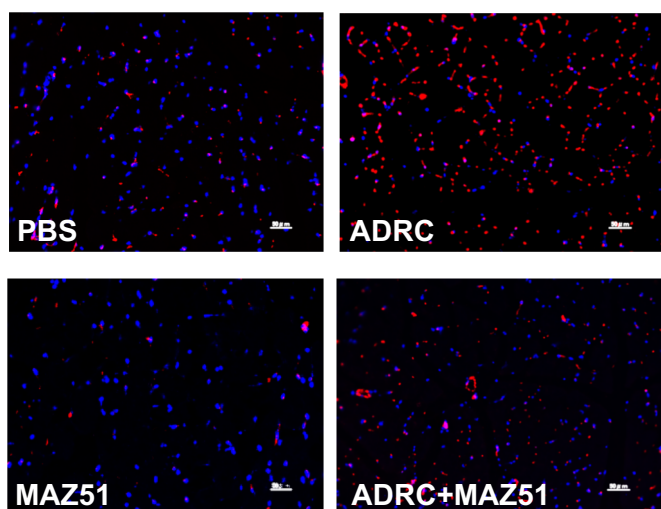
Suppression of lymphangiogenesis has adverse effects on the clearance of local inflammation/tissue edema and upregulates the anti-angiogenic cytokines in HLI. (A) Magnetic resonance imaging (MRI) by T2W signal to detect the tissue edema as the high intensity (white color). (B) Δ
